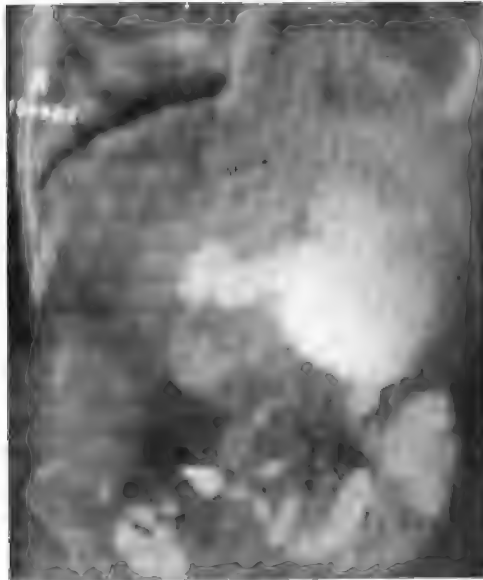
Roentgenogram of stomach following operation.
